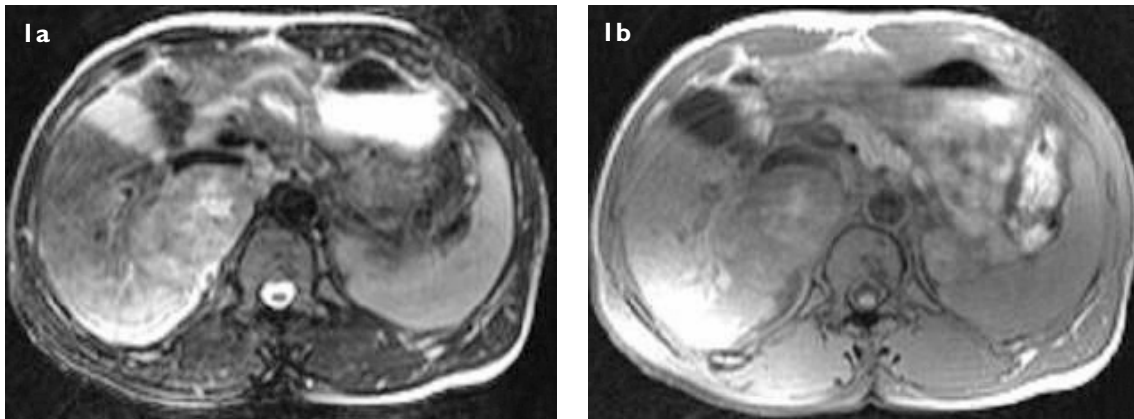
Axial (a) fat-suppressed T2-W, and (b) fat-suppressed T1-W MR images show a heterogeneous exophytic mass (arrow) in relation to segment VII of the liver.
